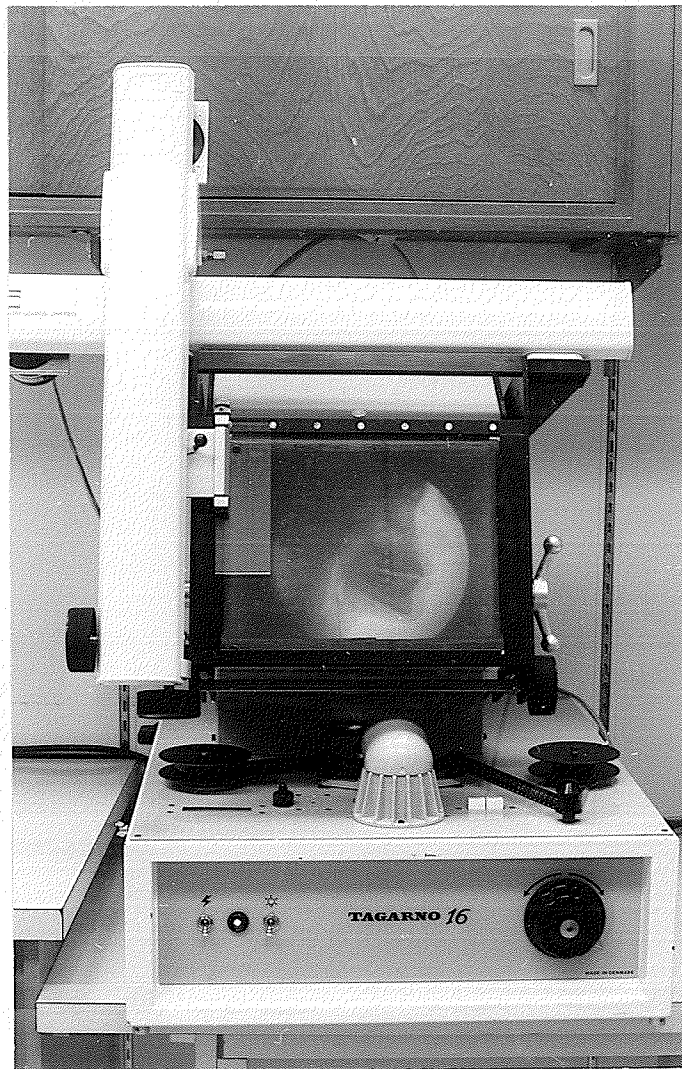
Photograph of Tagarno 16 Movie Projector and attached Ruscom Strip Chart Digitizer used to select and analyse the individual cinefluorographic frames and cephalometric radiographs.
